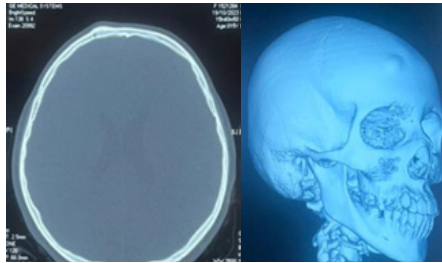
CT scan showing thickening of the outer cortex on the right side of the frontal bone.
